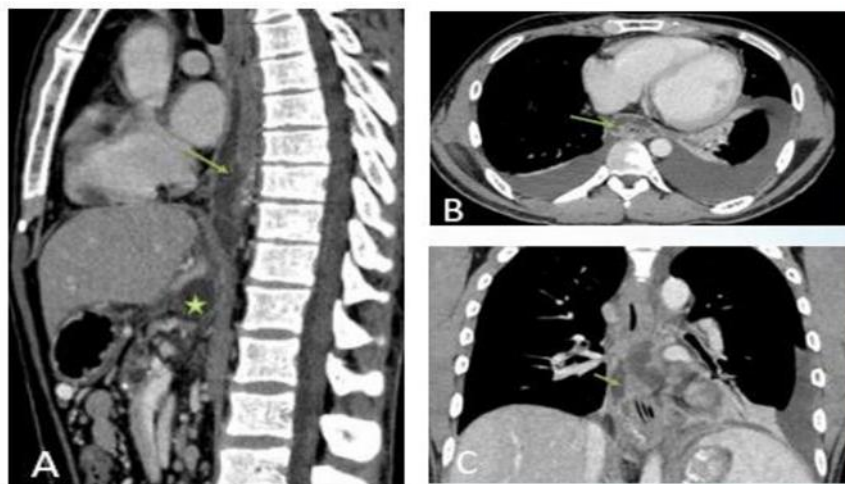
Contrast-enhanced CT images (A – sagittal, B – axial, C – coronal) showing a peripherally enhancing pancreatic collection (star) with superior extension along the esophageal hiatus into the posterior mediastinum (arrows), consistent with pancreatico-mediastinal fistula, associated with bilateral pleural effusions.
